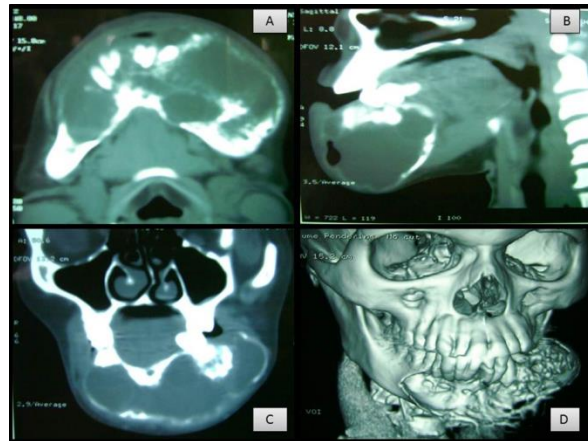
A) Axial CT scan showing a well defined multilocular lesion with bicortical expansion and multiple perforations. B) Sagittal CT section showing a large hypodense lesion with bicortical expansion and perforation with soft tissue invasion. C) Coronal CT showing a large expansile lytic lesion with multilocular soap bubble appearance. D) 3D CT showing a large destructive lesion of mandible extending from right first molar to left third molar region.
